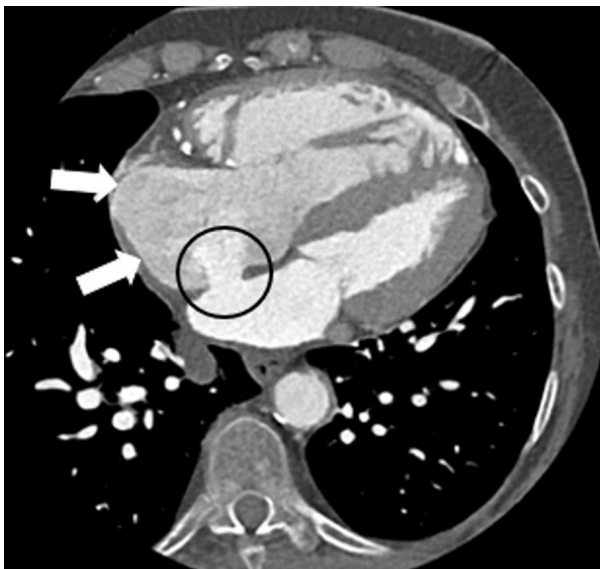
CT scan with contrast demonstrating defect within the wall of the atrial septum with evidence of contrast flow from left atrium to right consistent with a left to right shunt (circle) with an associated dilation of the right atrium (RA) (white arrows) consistent with volume and pressure overload of the RA due to shunting. Also notable is LV hypertrophy and RV dilation with an RV:LV ratio >1. See Figure 8 legend for expansion of other abbreviations.
